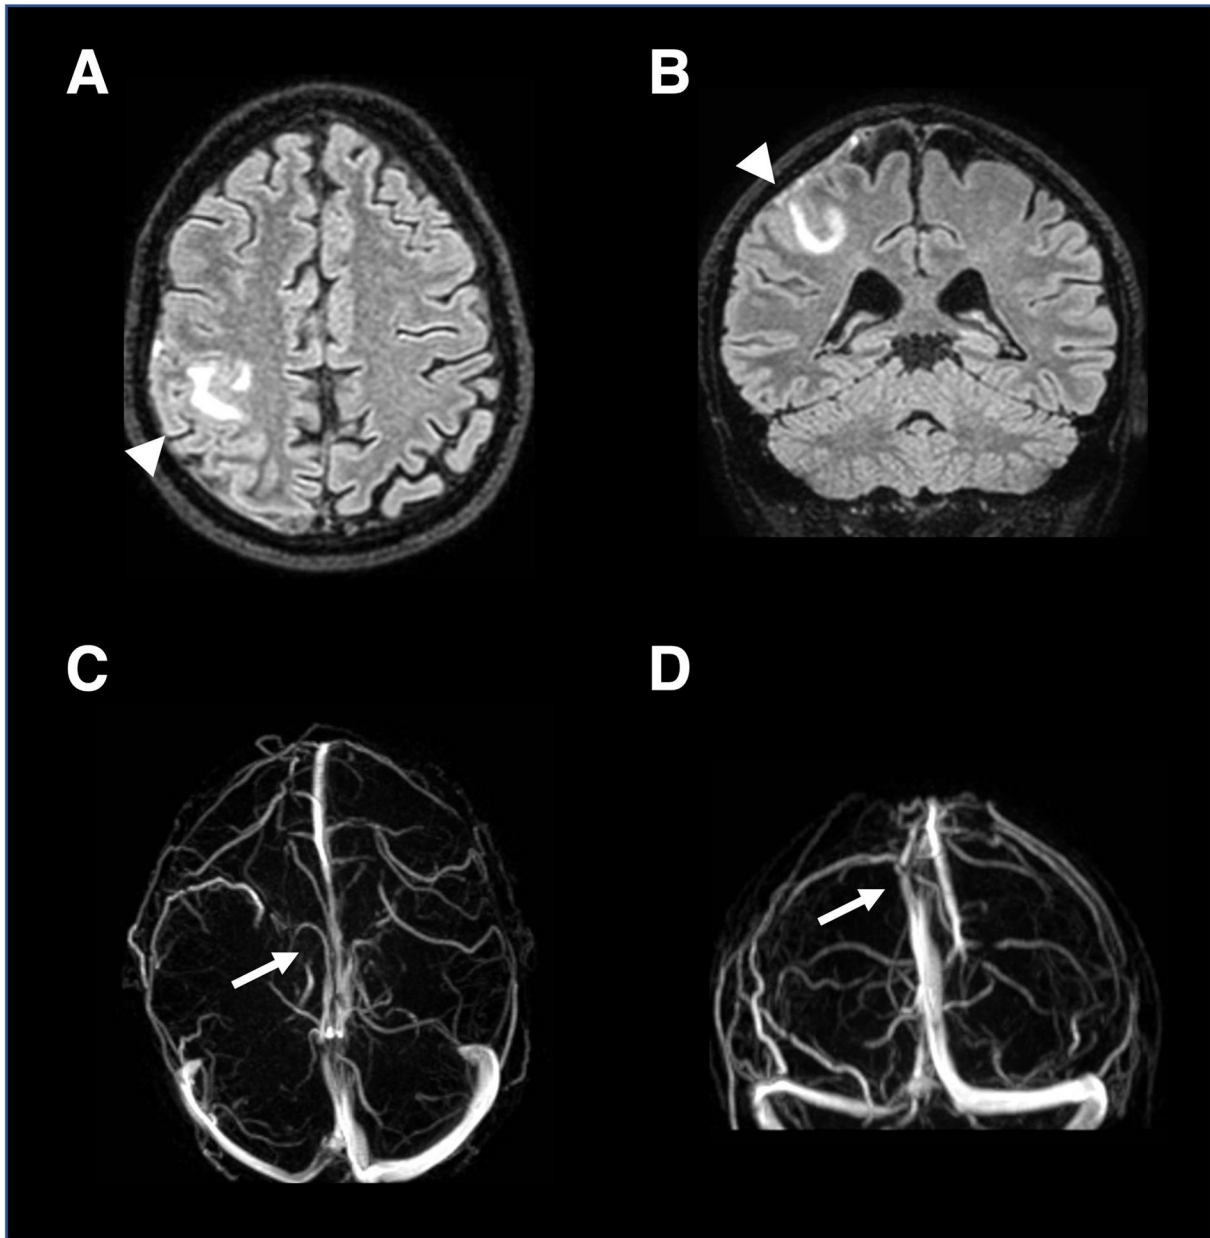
Brain MRI and MR venography findings. MRI (A) axial and (B) coronal sequences showing right parietal fluid-attenuated inversion recovery hyperintensity involving postcentral and precentral gyri (arrowhead). MR venography displaying superior sagittal sinus stenosis (arrows) in (C) axial and (D) coronal views. MR, magnetic resonance; MRI, MR imaging.
